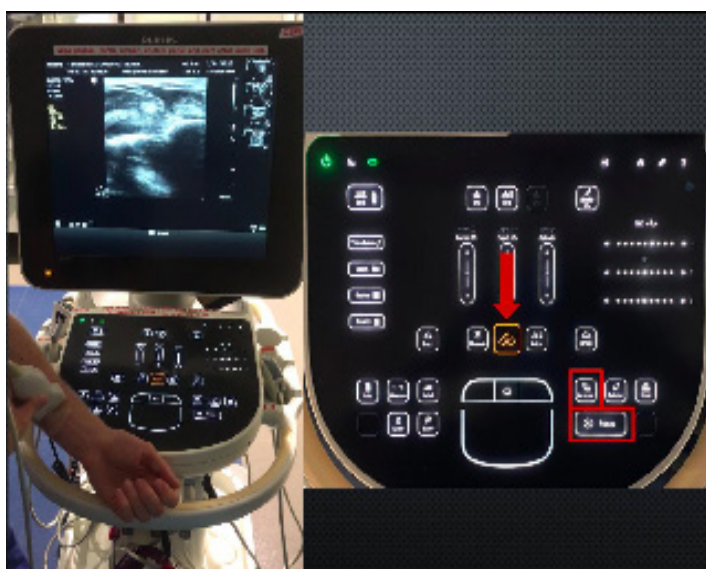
Image captured from Ultrasound Basics Training video (available at <https://youtu.be/ppv6y1tsF4>) which demonstrates how to acquire images on the machine.
